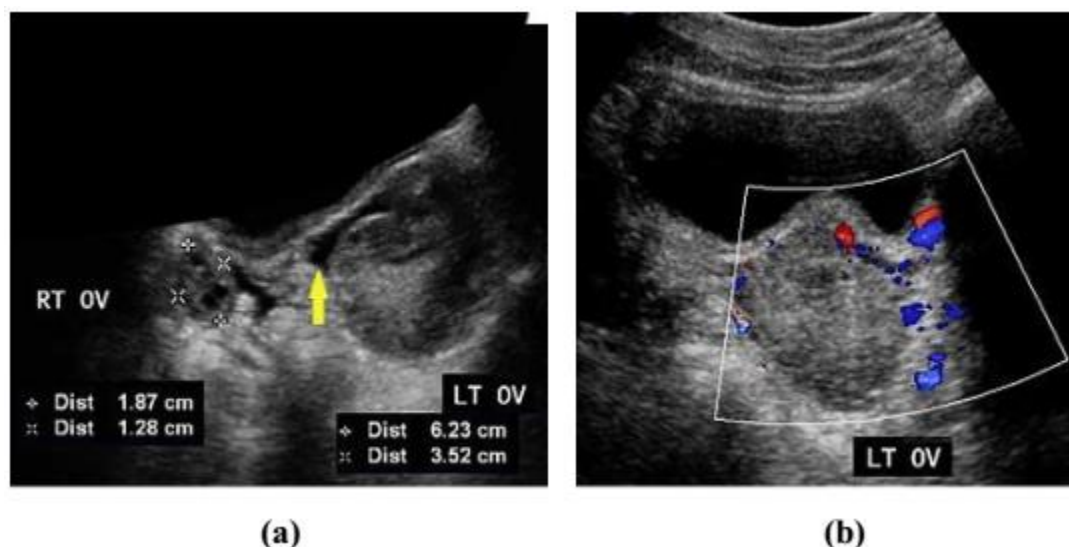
Transabdominal US images from a 9 yr old girl with torsed Lt ovary. (a) Note the enlarged Lt ovary in the absence of masses, its maximum dimension was 6.2 cm, as well as the free pelvic collection (yellow arrow), the tiny peripherally arranged follicles and the central afollicular stroma. (b) Absent intraovarian vascularity by Color Doppler US (33).
